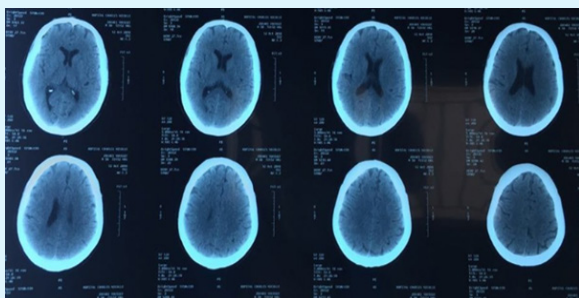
Cerebral non-enhanced computed tomography performed shortly after the onset of symptoms without abnormalities.
